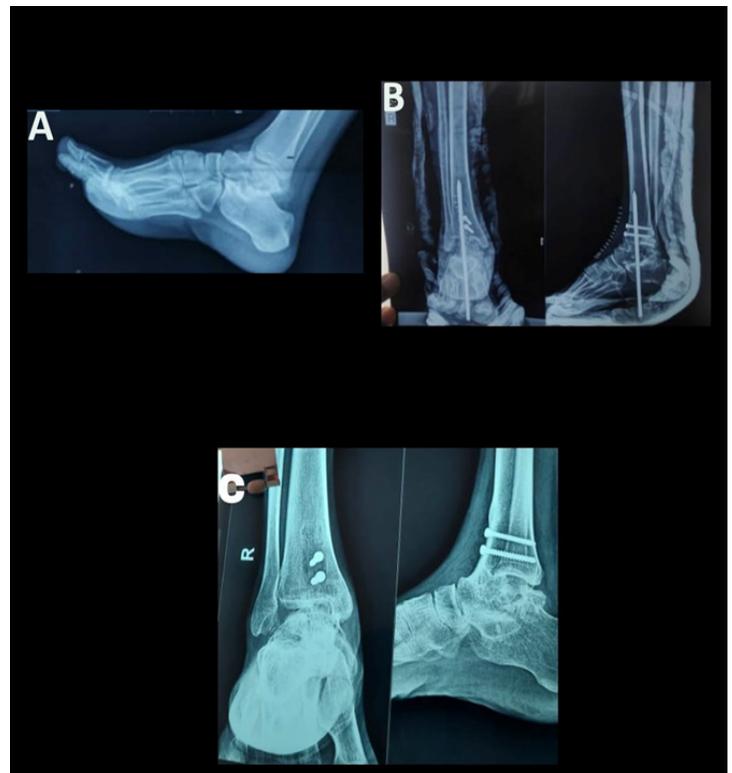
a) X-ray at the time of injury showing Hawkins type III fracture b) immediate post-op X-ray c) X-ray after 1 year of surgery
